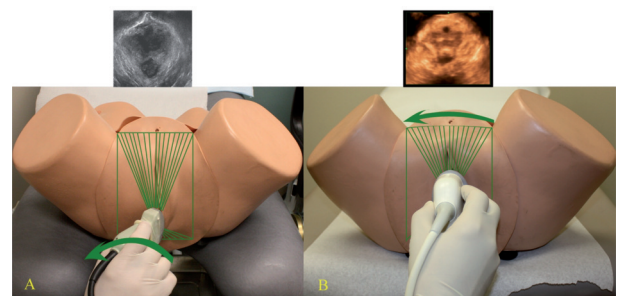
Freehand 3D transperineal ultrasound shows freehand movement of probe. The hand sweeps from patient's left to right at a constant speed to obtain a 3D volume.
